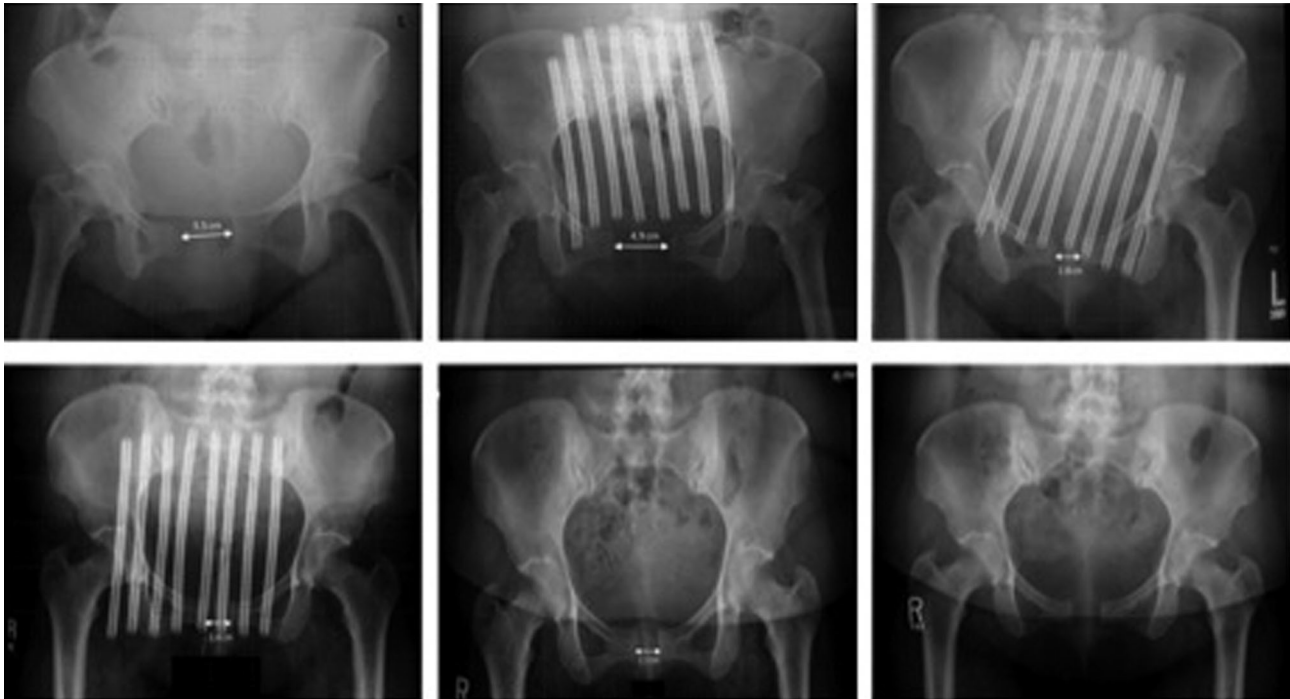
AP radiographs. A) PPD 1, diastasis 5.5 cm; B) PPD 3, diastasis 4.9 cm with binder; C) PPD 15, diastasis 2.8 cm with binder; D) Four weeks, 2.4 cm with binder; E) Three weeks, 2.1 cm without binder; F) 15 months, 2.4 cm without binder.
